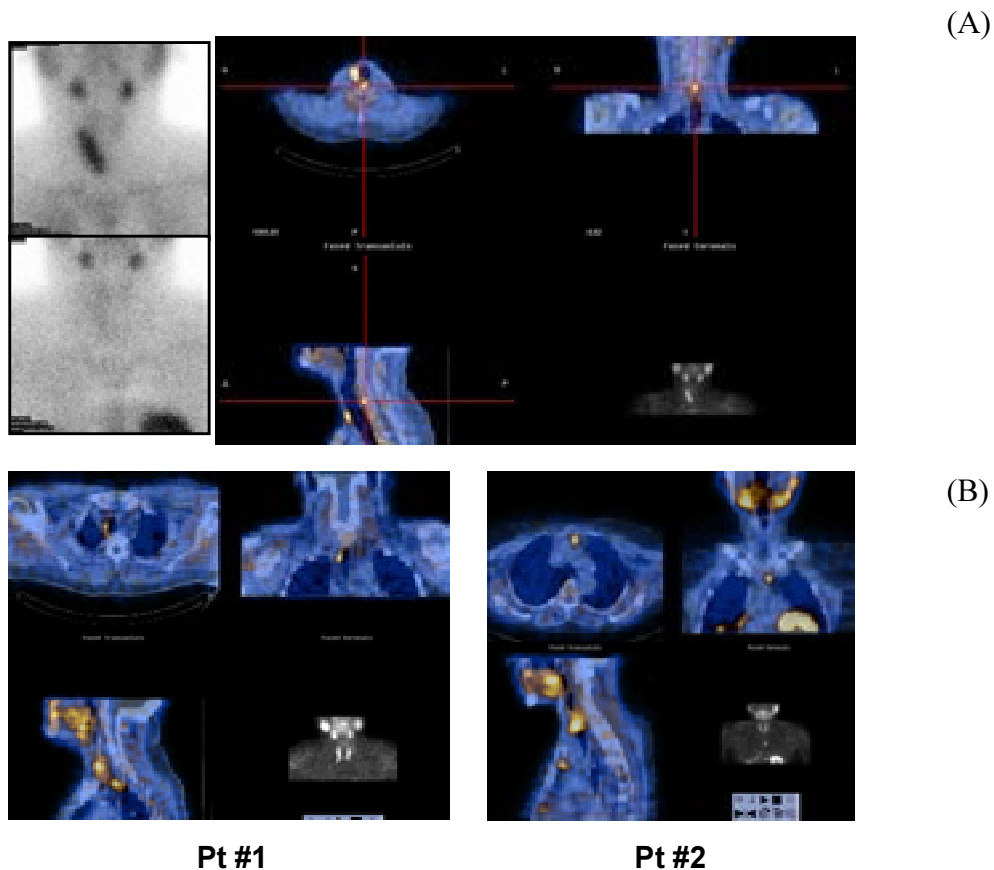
Patients with parathyroid adenomas in whom hybrid SPECT/CT imaging turned out to be crucial for accurate preoperative localization and for planning the most adequate surgical approach. (A) Early (top left) and delayed (bottom left) planar ^{99m}Tc -sestamibi scans in a patient who had undergone unsuccessful parathyroid surgery during which the left thyroid lobe was also resected because of concomitant nodular goiter (persistent primary hyperparathyroidism despite removal of an enlarged parathyroid gland ectopically located in the anterior mediastinum that had been identified on a planar ^{99m}Tc -sestamibi scan). While both scans (left panels) are negative for parathyroid adenoma, SPECT/CT imaging (right panel) enabled to identify abnormal tracer uptake located posteriorly to the trachea. (B) Two patients in whom SPECT/CT imaging with ^{99m}Tc -sestamibi localized hyperfunctioning parathyroid adenomas and led to plan the optimal surgical approach for their successful resection. In Pt #1 the adenoma was located adjacent to the right wall of the trachea, while in Pt #2 the adenoma was located in the anterior mediastinum.
